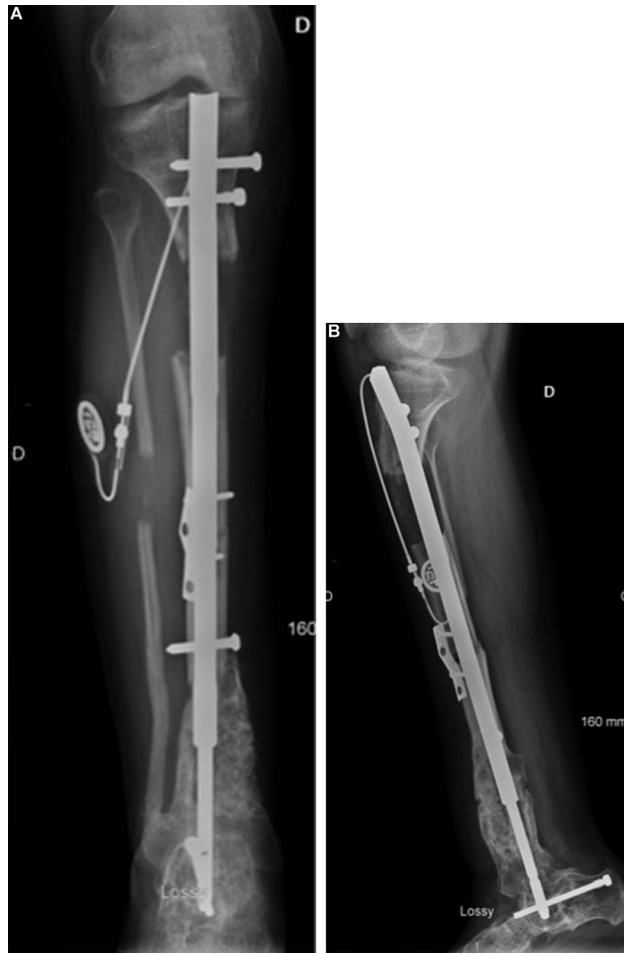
Radiographs taken 4 months after implantation of the motorised nail, showing a small callus at the proximal metaphysis and a deformity with 30° of flexion and 15° of valgus; note the cut-out of a proximal locking nail.
